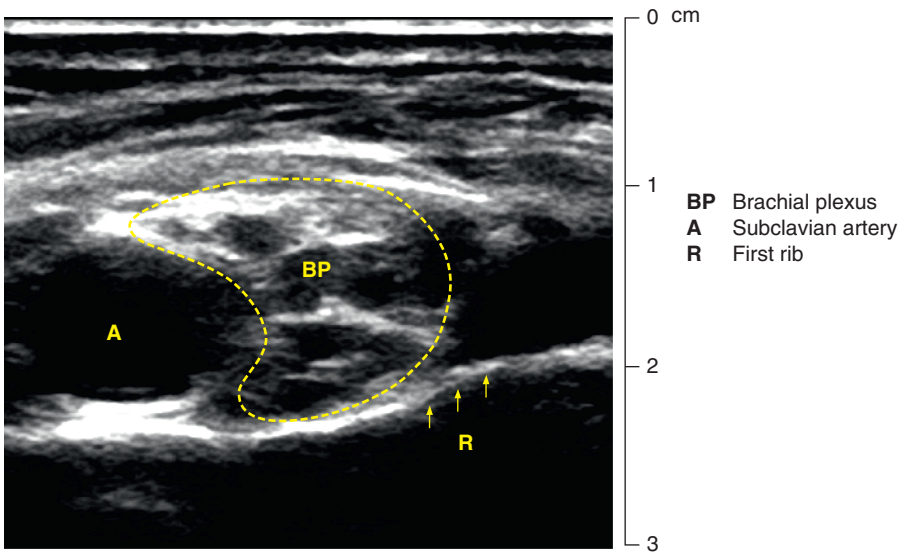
Vascular and bony landmarks in an ultrasound scan: locating the brachial plexus
